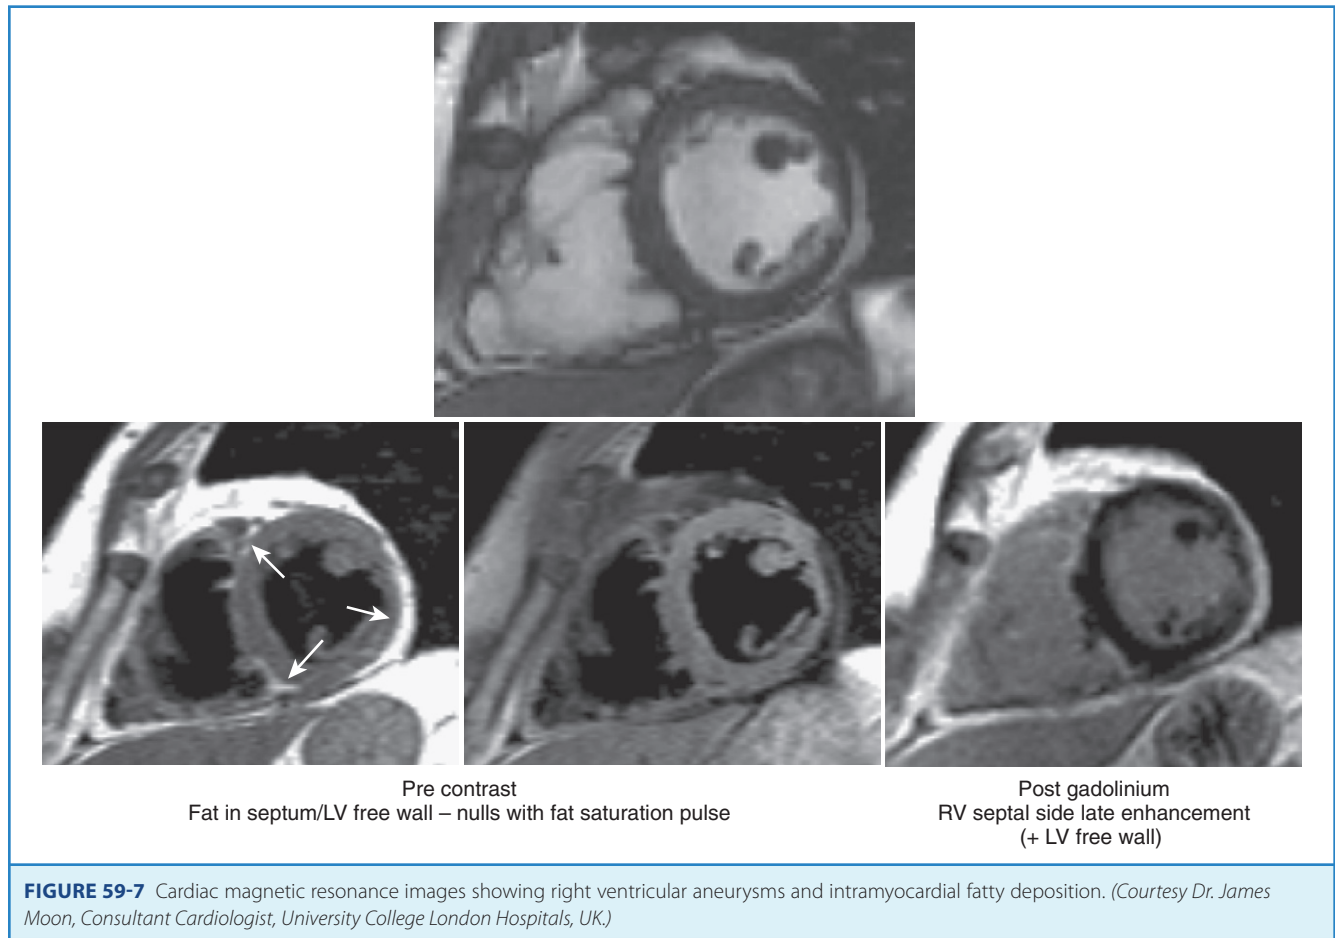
Cardiac magnetic resonance images showing right ventricular aneurysms and intramyocardial fatty deposition. (Courtesy Dr. James Moon, Consultant Cardiologist, University College London Hospitals, UK.)
